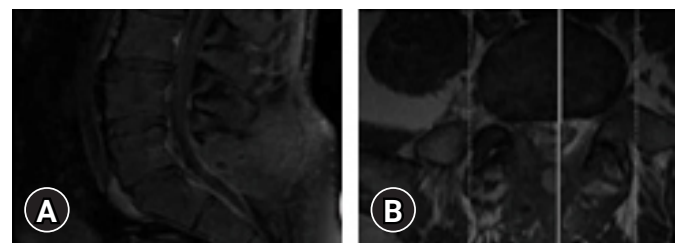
(A) Postoperative sagittal T1-weighted MRI with gadolinium enhancement displaying no remnant tumor or recurrence. (B) Postoperative axial T1-weighted MRI with gadolinium enhancement displaying no remnant tumor or any recurrence.
